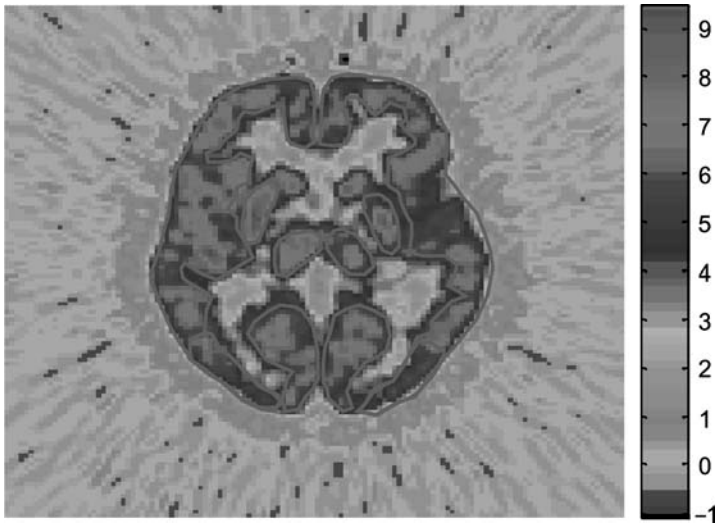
Representative RoIs defined for the quantitative evaluation of brain PET data acquired with  $^{18}\text{F}$ -FDG in a normal brain. The color bar has relative units due to the image reconstruction filtering.
